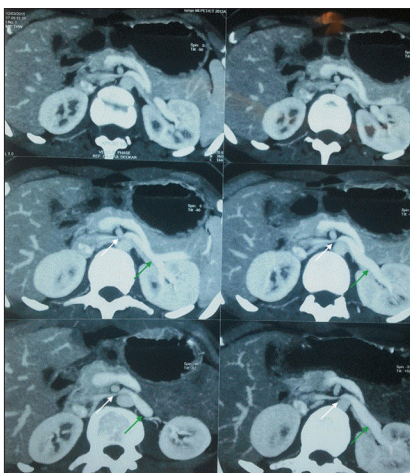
Axial Computed tomographic images with intravenous contrast in portal venous phase showing nutcracker phenomenon. Left renal vein is compressed between the aorta and the superior mesenteric artery (white arrow). Left renal vein with distended hilar portion (green arrow)
